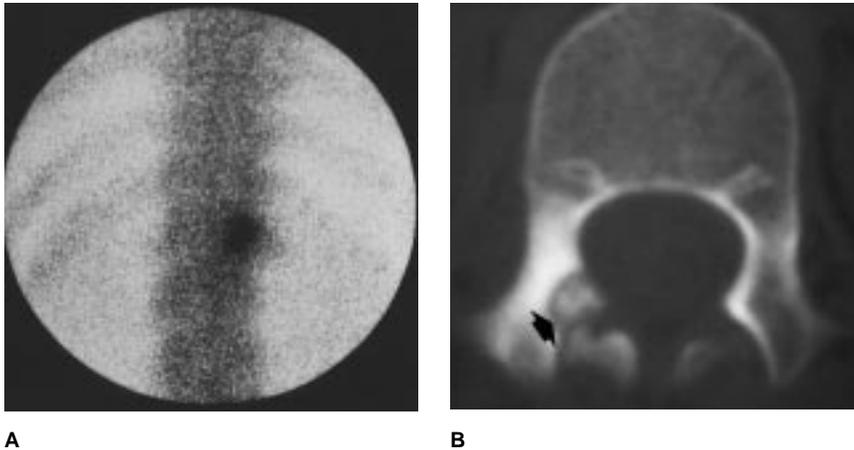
A, Bone scan shows increased uptake representing osteoid osteoma in pedicle of L1. B, Axial CT scan shows nidus (arrow) in pedicle and surrounding sclerosis.
